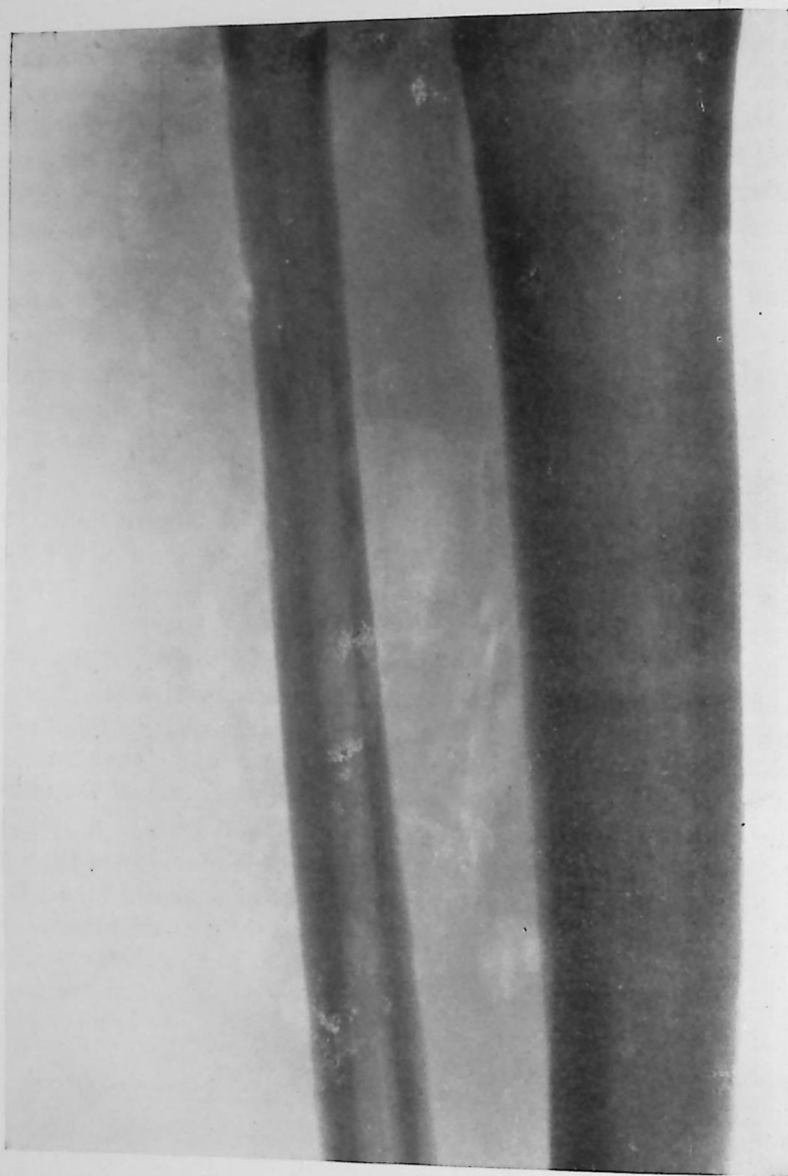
Radiograph showing gas in the tissue spaces. The appearance was produced by the application of sodium hypochlorite to a small wound in the leg.
